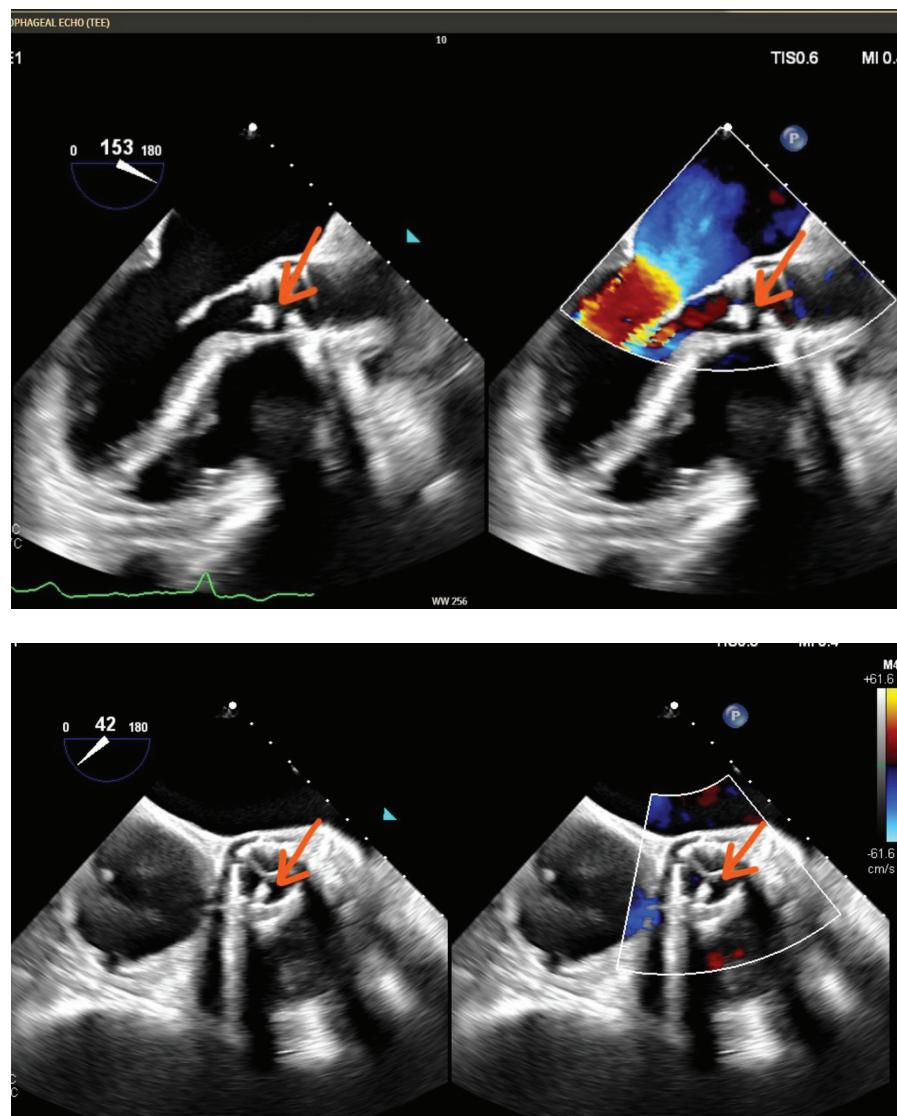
Trans-esophageal echocardiography showing TAVR aortic prosthetic valve vegetations. The orange arrow shows a nodular echodensity on the TAVR aortic valve.
